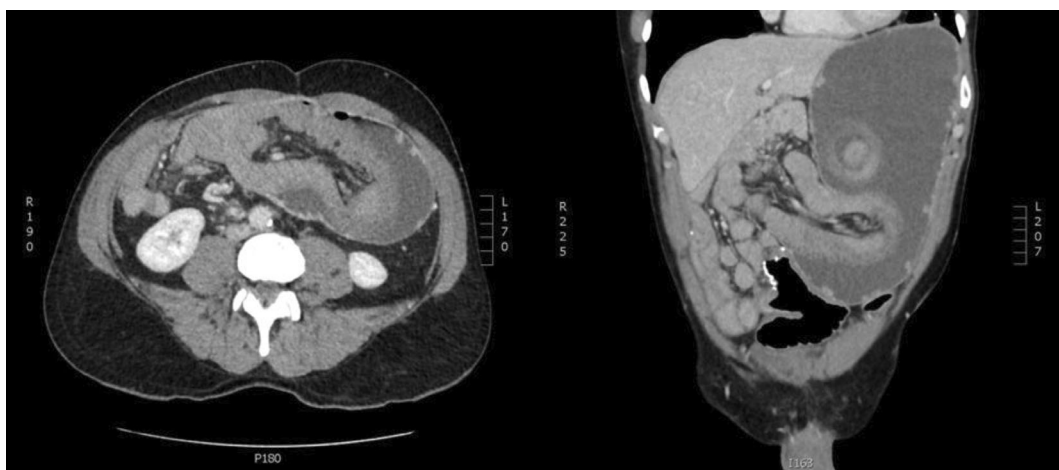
Axial and coronal CT evidence of intussusception.
